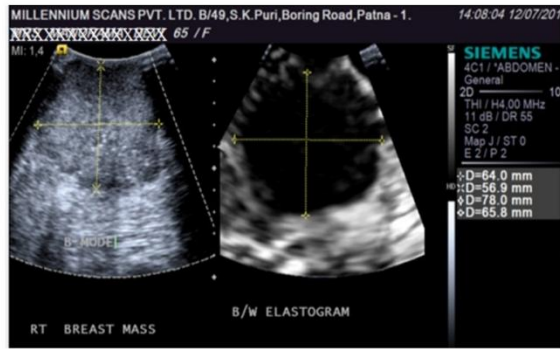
ELASTOSONOGRAPHY OF MALIGNANT BREAST LESION
